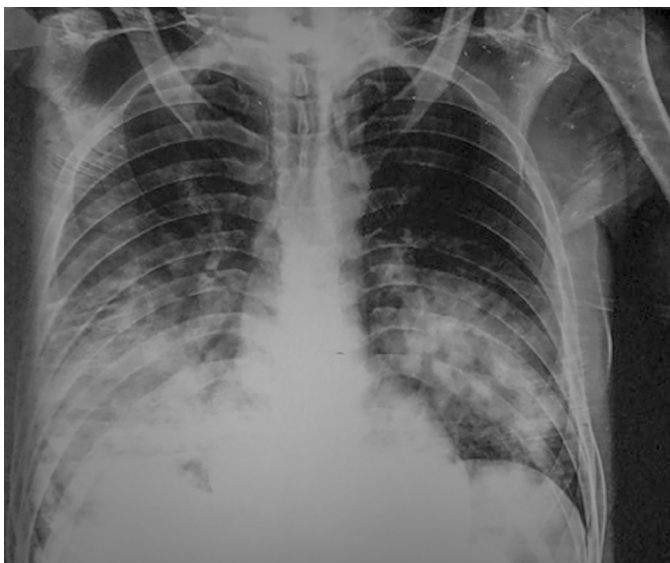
Chest X-ray. Posterior-anterior projection. Bilateral alveolar infiltrates at the bases, with left predominance and bilateral progressive diffusion, compatible with ground glass opacification images.
